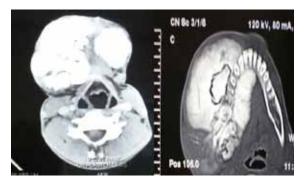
Plain & contrast enhanced CT scan showing heterogeneously enhancing ill defined fibro-osseous lesion in the mandible involving adjacent spaces and also bone destruction.
